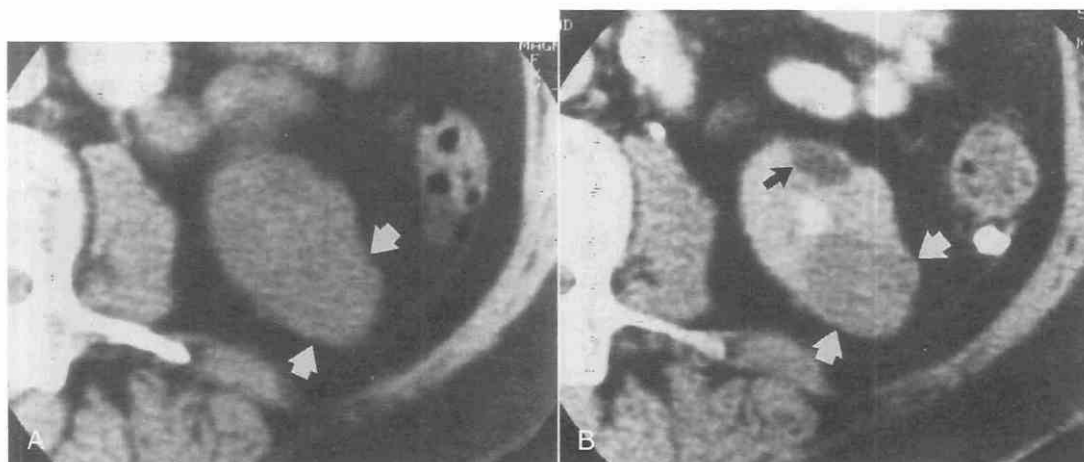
Renal cell carcinoma. A, The neoplasm (arrows) has a similar density to normal renal parenchyma on an unenhanced CT scan. B, A contrast-enhanced CT scan shows a homogeneous 2.3-cm mass (white arrows) with a slightly irregular outline. The attenuation value increased from 37 to 87 HU. A small renal cyst (black arrow) is seen anteriorly.
